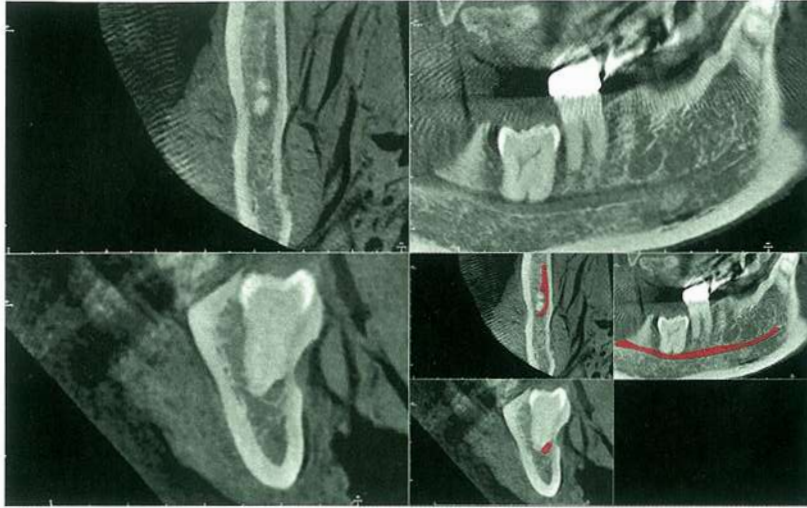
Impacted third molar. The roots can cause deviation or narrowing of the canal. *Red highlighting* emphasizes the proximity of the roots to the canal. This MPR CBCT reconstruction shows that care must be taken when planning treatment.
